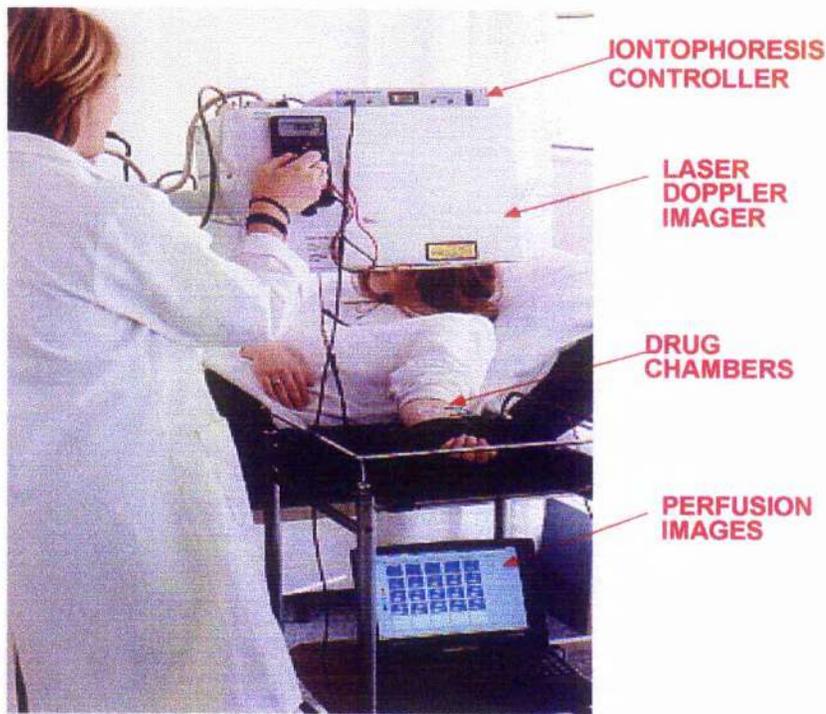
Laser Doppler Imager and iontophoresis set-up.
